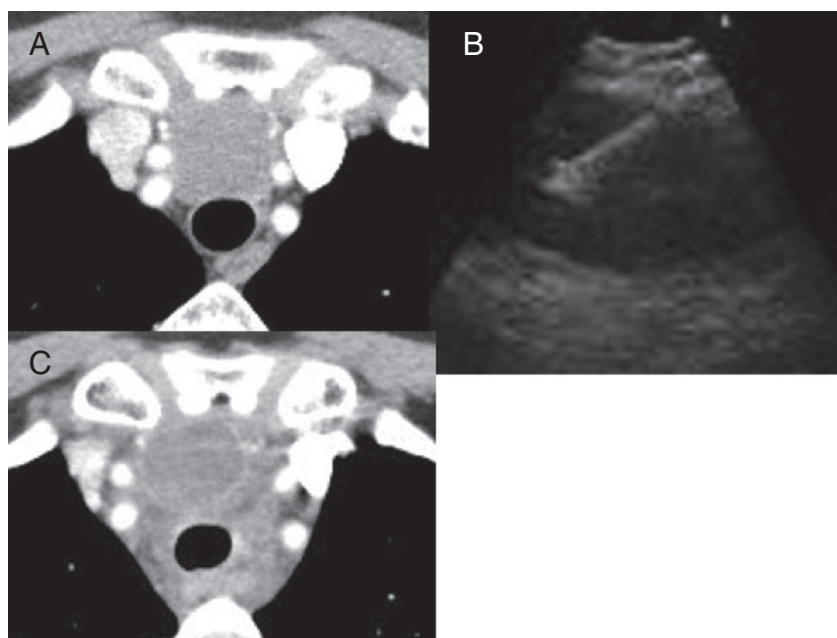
Computed tomography (CT) and endobronchial ultrasound (EBUS) of the mediastinal cyst. (A) The CT image before EBUS revealing an anterior mediastinal cyst. (B) The EBUS-TBNA on the cyst showing the aspiration needle. (C) The CT image showing mediastinitis after EBUS-TBNA.
